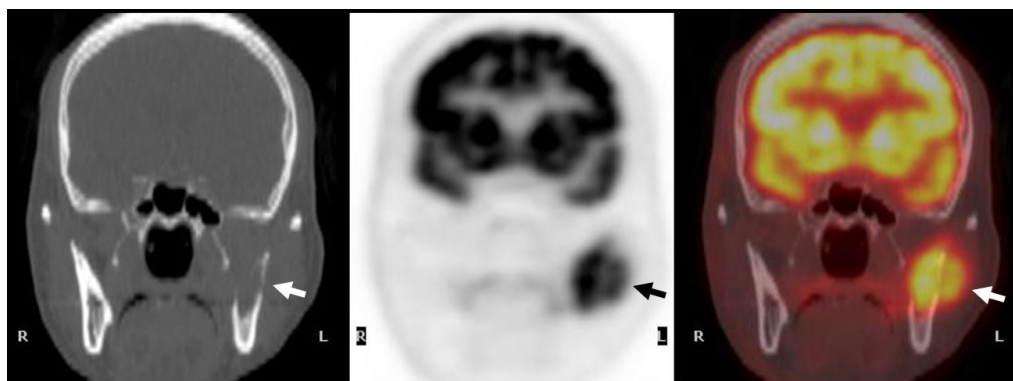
Coronal view of CT image, PET image and fused image showed hypermetabolic bone destruction at left ramus of mandible (arrow) that caused NCS in this patient.
